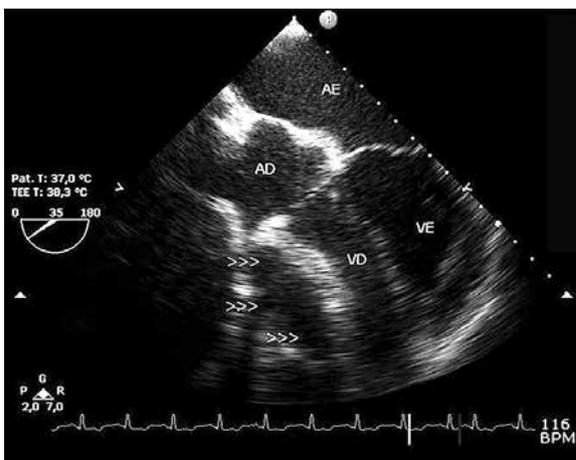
Image from transesophageal with visualization of the four heart chambers demonstrating extrinsic compression of right chambers by a large cystic formation (arrowheads) and pericardial thickening. Source: personal archive.
